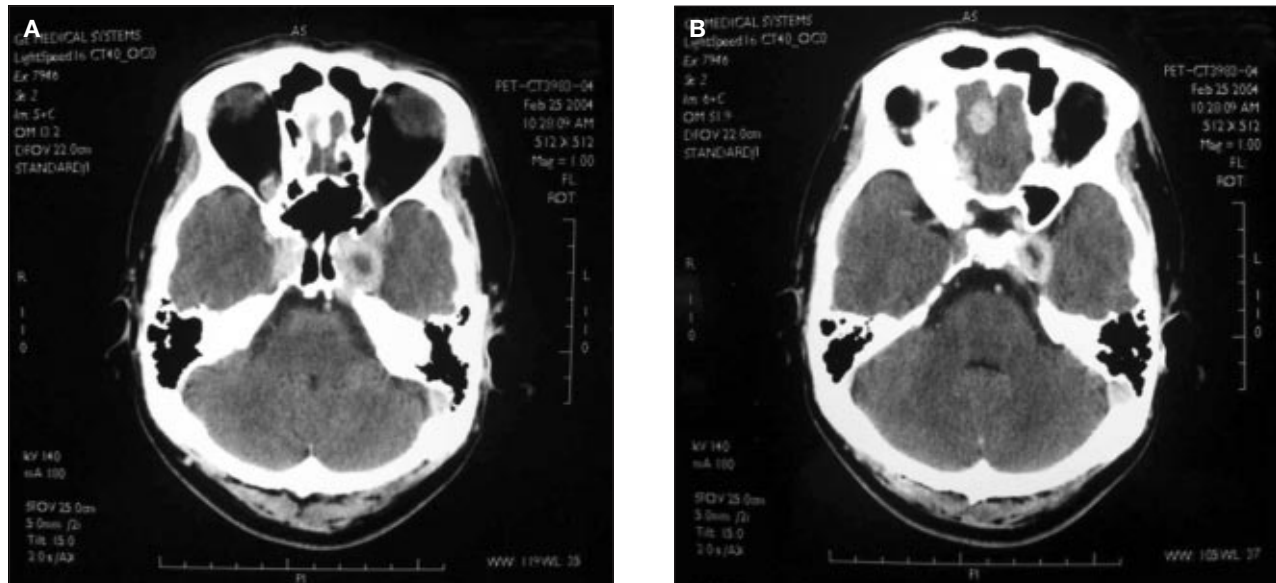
Computed tomography scan of Patient 1 showing contrast-enhanced extra-axial brain lesions in both parasellar regions, right anterior cranial fossa, and right orbital apex without surrounding edema.
